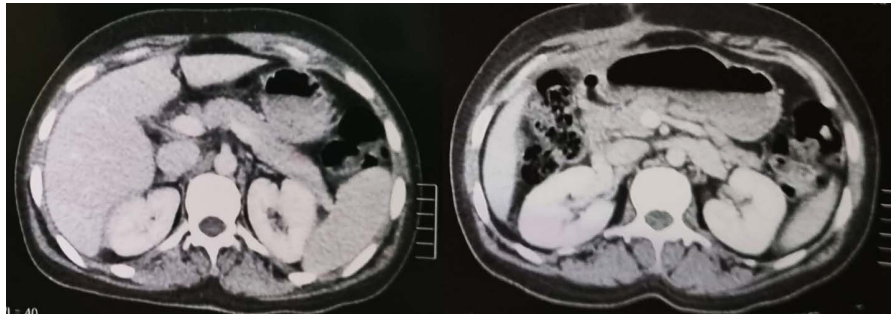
Abdominal CT: Total disappearance of the subcapsular collection along with the free fluid around the liver.
